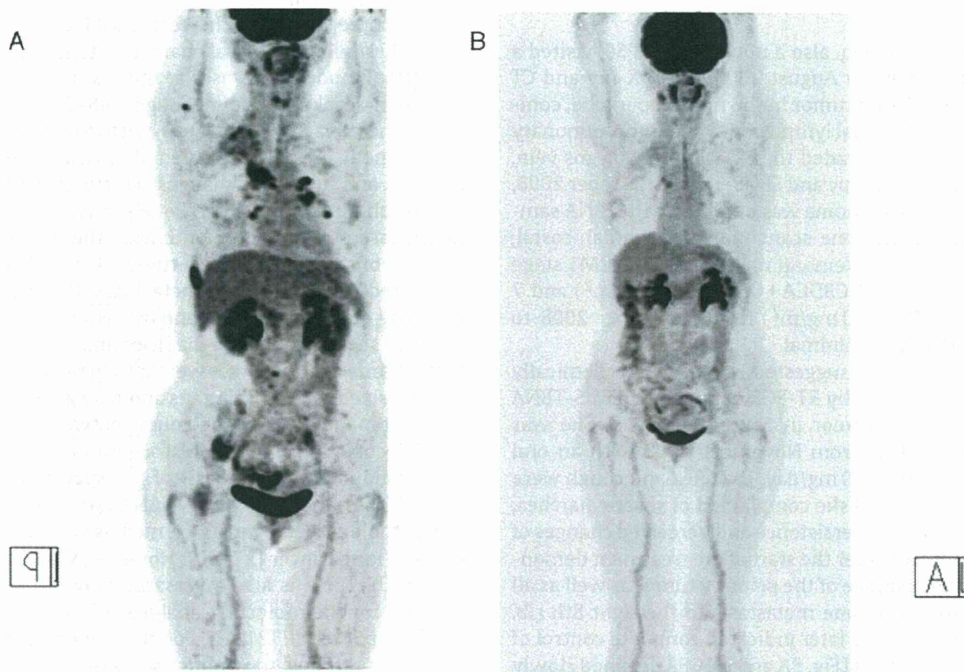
FDG-PET scan: A, 09/08/2009 (before ALK inhibitor) and B, 07/05/2010 FDG-PET scan follow-up for 10 months indicated complete control of primary and distant metastases in case 3.
